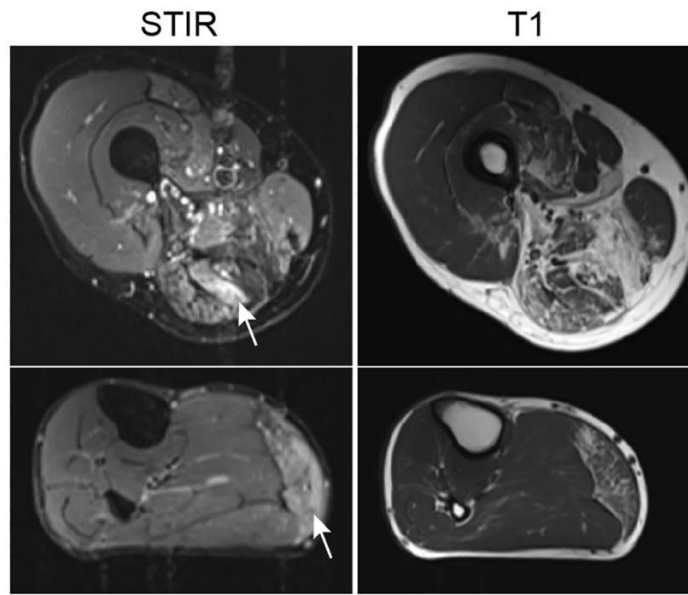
MRI reveals STIR lesions (arrows) of the semitendinosus and medial gastrocnemius muscles. T1 images reveal fat replacement.
